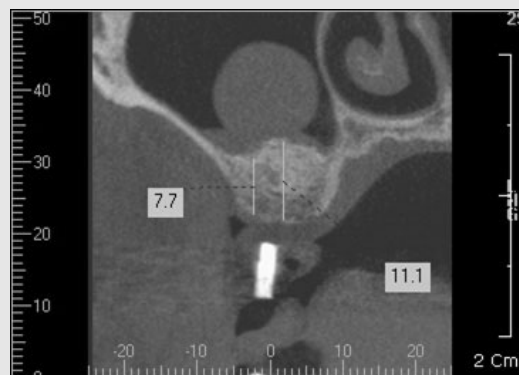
After sinus floor elevation, cone beam CT finding shows the remaining radiopaque lesion.
